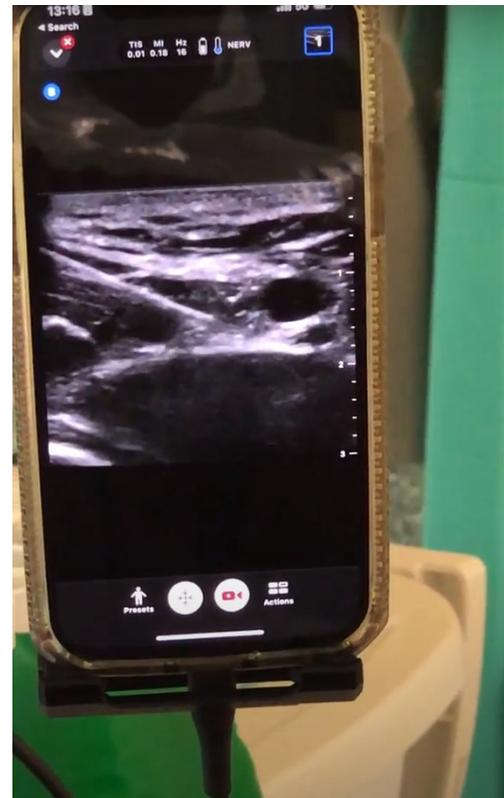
Dr. Brian O'Donnell taught the anatomical landmarks for the brachial plexus block using butterfly ultrasound and placing the needle adjacent to the median nerve complex to inject local anesthesia.
